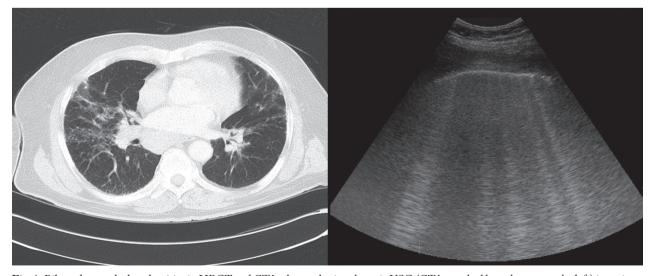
Bilateral ground-glass densities in HRCT and CTAs detected using thoracic USG (CTAs marked by red arrow on the left) in patients with sarcoidosis. On the monitor, CTAs start with a narrow baseat the visceral pleural region and extend towards the peripheral along the monitor.
